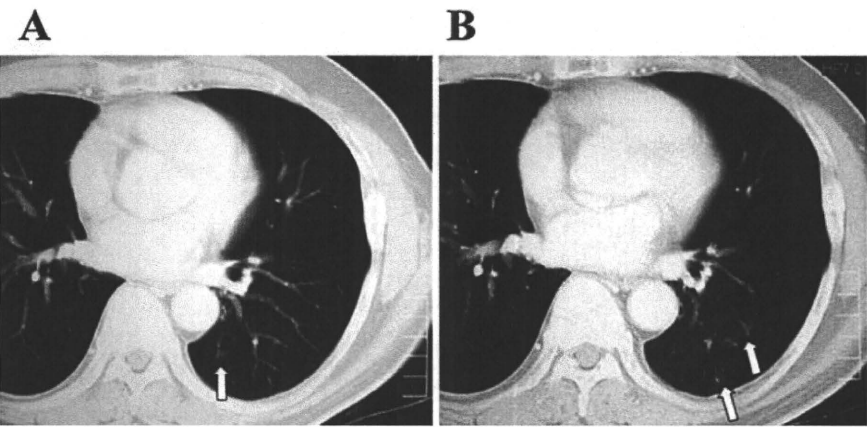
Computed tomography images from a 60-year-old man. A CT scan showing a small, pure GGO in the left lower lobe of the lung (arrow). B At the 45-month follow-up, the lesion had increased slightly in size and multiple new GGOs had appeared (arrows)
